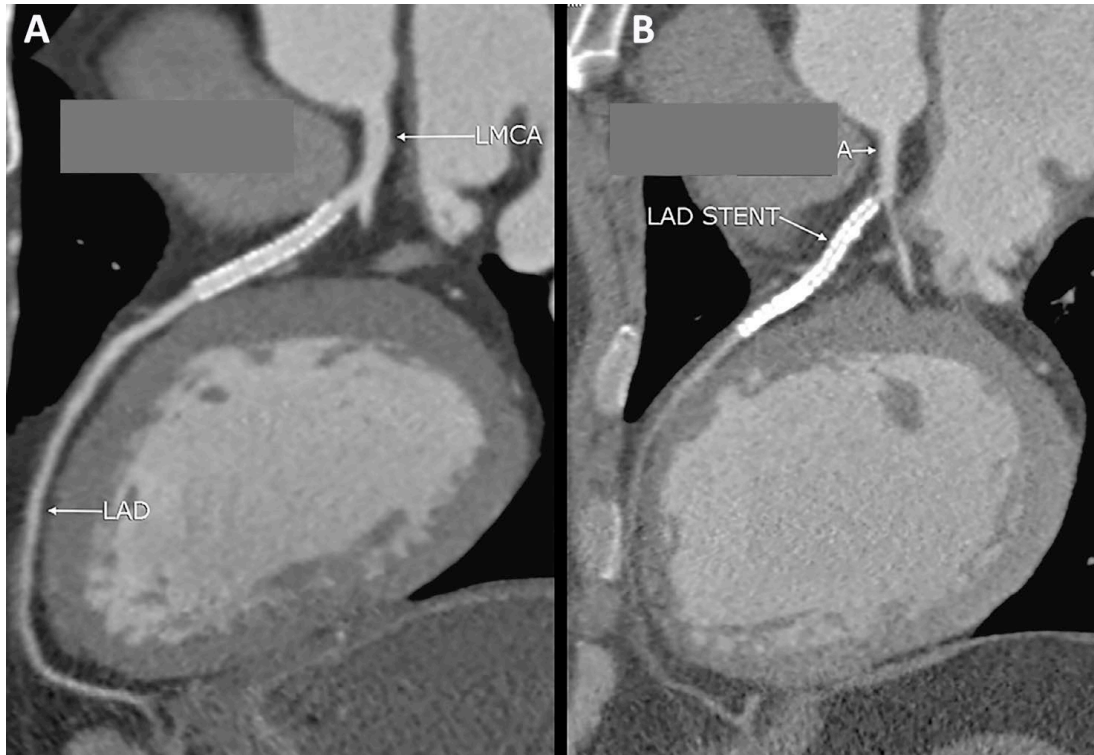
The LAD stent imaged in a higher version machine, the uCT 780 (United Imaging Healthcare, Shanghai, China) 160 slice cardiac CT scanner. Panel A shows remarkable clarity of the in-stent lumen as compared to the lower version machine study performed a few years earlier shown in Panel B.
